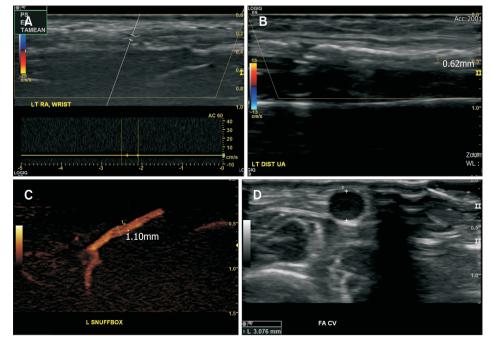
Preoperative duplex ultrasonography evaluation of the left forearm vessels. (A) At the wrist level, the radial artery was completely occluded. (B) The distal ulnar artery was occluded with severe calcification. (C) The radial artery in the anatomical snuffbox showed mild intraluminal stenosis due to atherosclerosis. However, the calcification was not severe and distal branch patency was observed. The artery was 1.7 mm in outer diameter and 1.1 mm in inner diameter. (D) The diameter of the forearm cephalic vein was approximately 2 to 3 mm.
